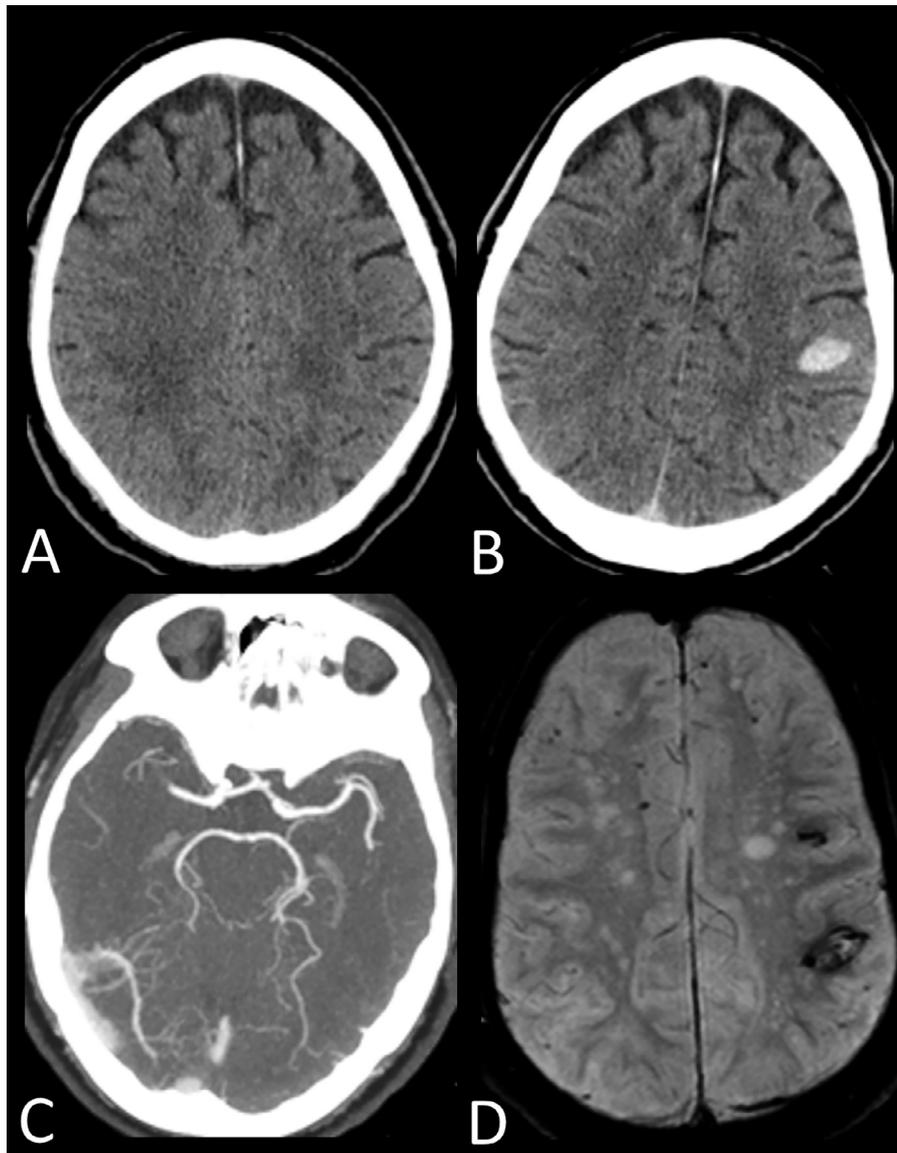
(A) Initial CT scan of the patient with acute onset left side hemiparesis. (B) Repeat CT scan after intravenous thrombolysis and transfer to our center; 1 of 3 left hemispheric intracerebral hemorrhages is shown. (C) Contrast-enhanced CT angiogram shows persistent occlusion of right middle cerebral artery, M1 segment, and thrombectomy was performed. (D) MRI 5 weeks later with T2*-weighted gradient echo sequence reveals microbleeds and residual hemorrhage.
